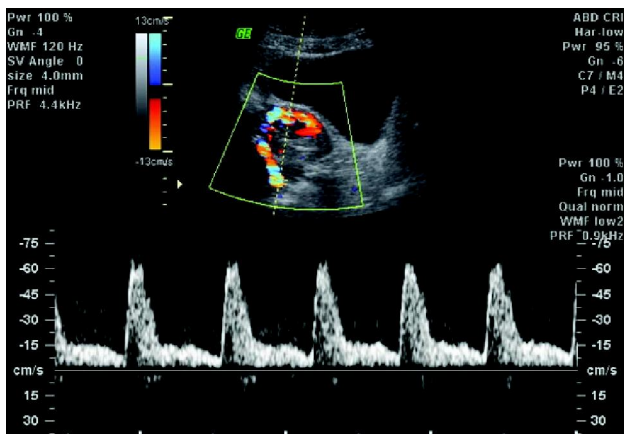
Trans abdominal ultrasound of the pelvis shows bulky uterus with increased vascularity and multidirectional flow on doppler.
